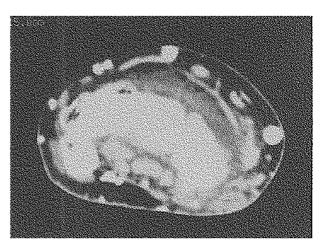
CT scan (enhanced slice).
